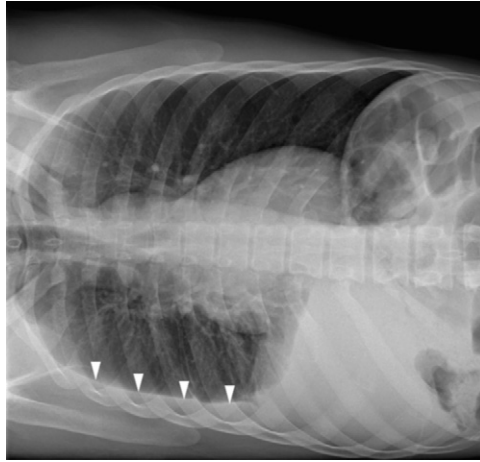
Lateral decubitus radiograph showing a small amount of free-flowing pleural fluid (arrowheads).
